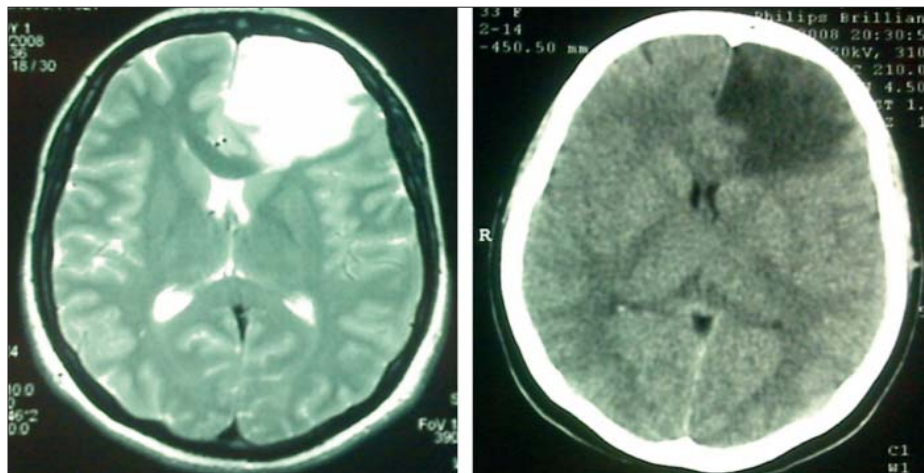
T1 and T2 MRI Aspect in a patient with left frontal low grade glioma
